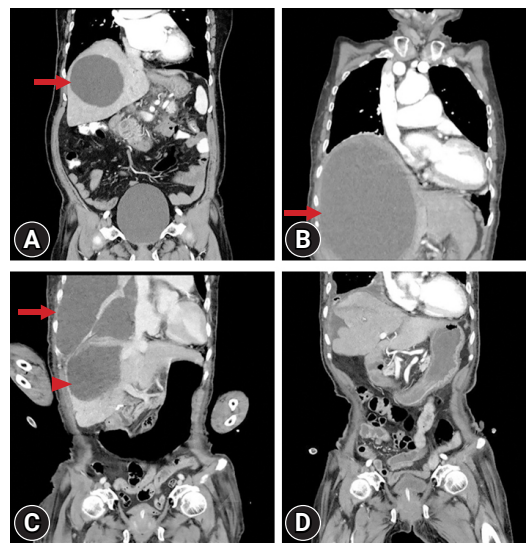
(A) Hepatic cyst (10 cm, arrow) noted by abdominal computed tomography (CT) 10 years ago. (B) CT scan taken at the internal medicine outpatient department 1 month before the visit to the emergency room shows the existing hepatic cyst enlarged to approximately 19 cm (arrow). (C) Abdominal CT at the time of admission to the emergency room shows a large amount of pleural effusion (arrow) and the hepatic cyst (arrowhead), which is significantly smaller than 1 month earlier. (D) One week after chest tube insertion, CT scan shows that most of the pleural effusion has drained, and the giant hepatic cyst has disappeared.
